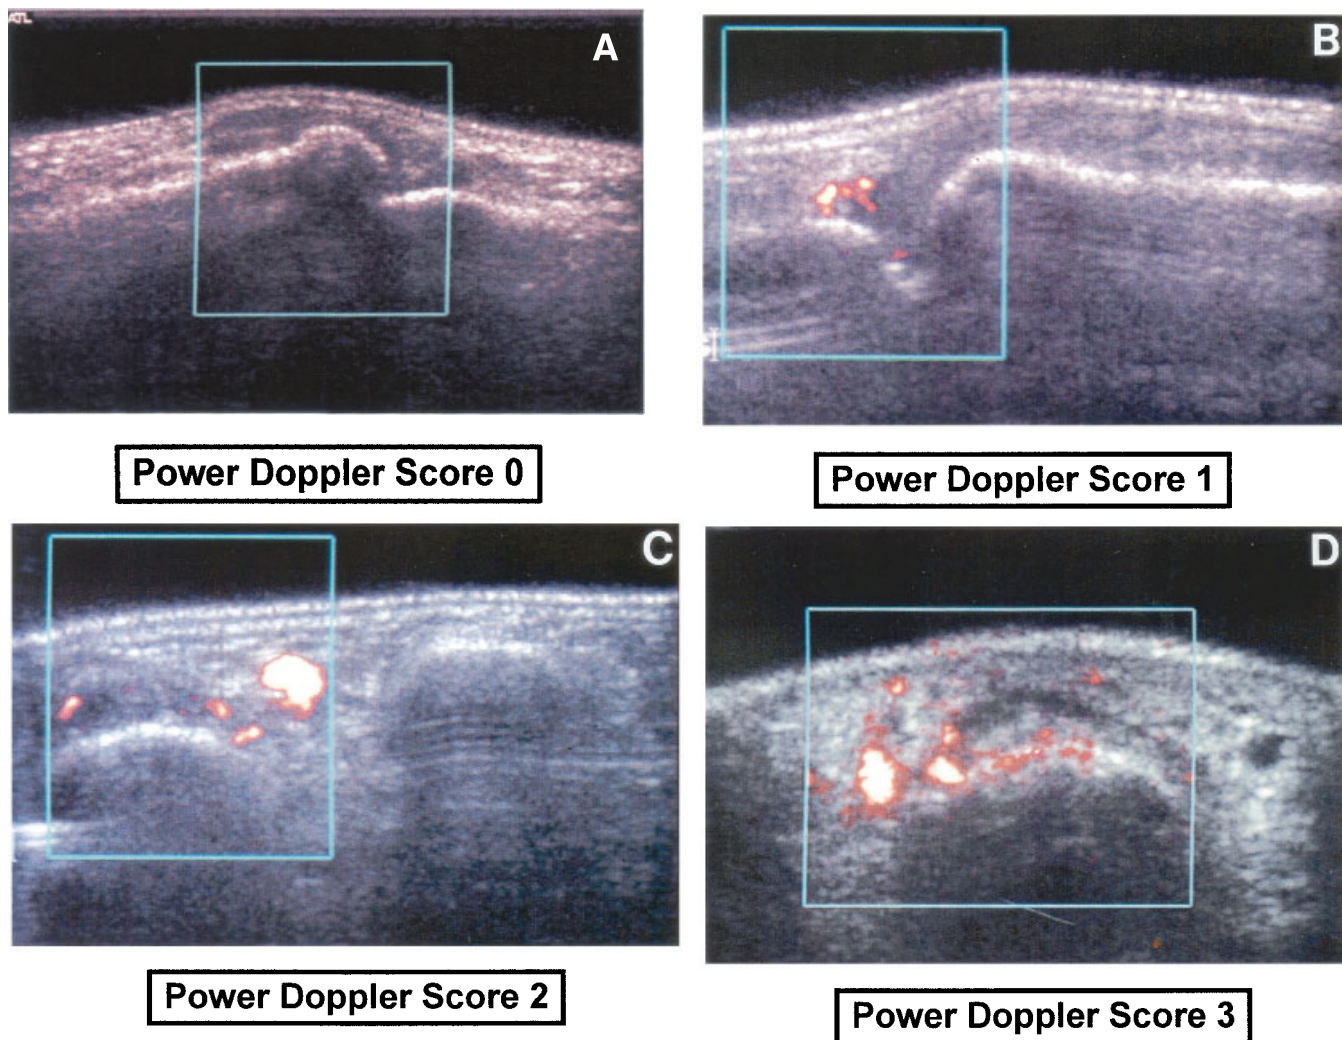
Image investigation techniques. With sonography, patients were evaluated according to a 5–12-MHz gray scale (HDI 5000; ATL Ultrasound, Bothell, WA) with B-mode and power Doppler application, using a standardized technique. The patient was seated at the scanning table opposite the investigating physician, with his or her hands placed flat on the table surface. Two radiologists and 2 radiology residents performed the evaluation (after thorough instruction), and the results were compared to determine precision and feasibility. Findings were interpreted in consensus, and if there was any disagreement among the investigators, the examination was repeated. Synthetic plastic blocks were used to improve contact between the surface of the transducer and the hands and fingers and to reduce near-field artifacts (14).
